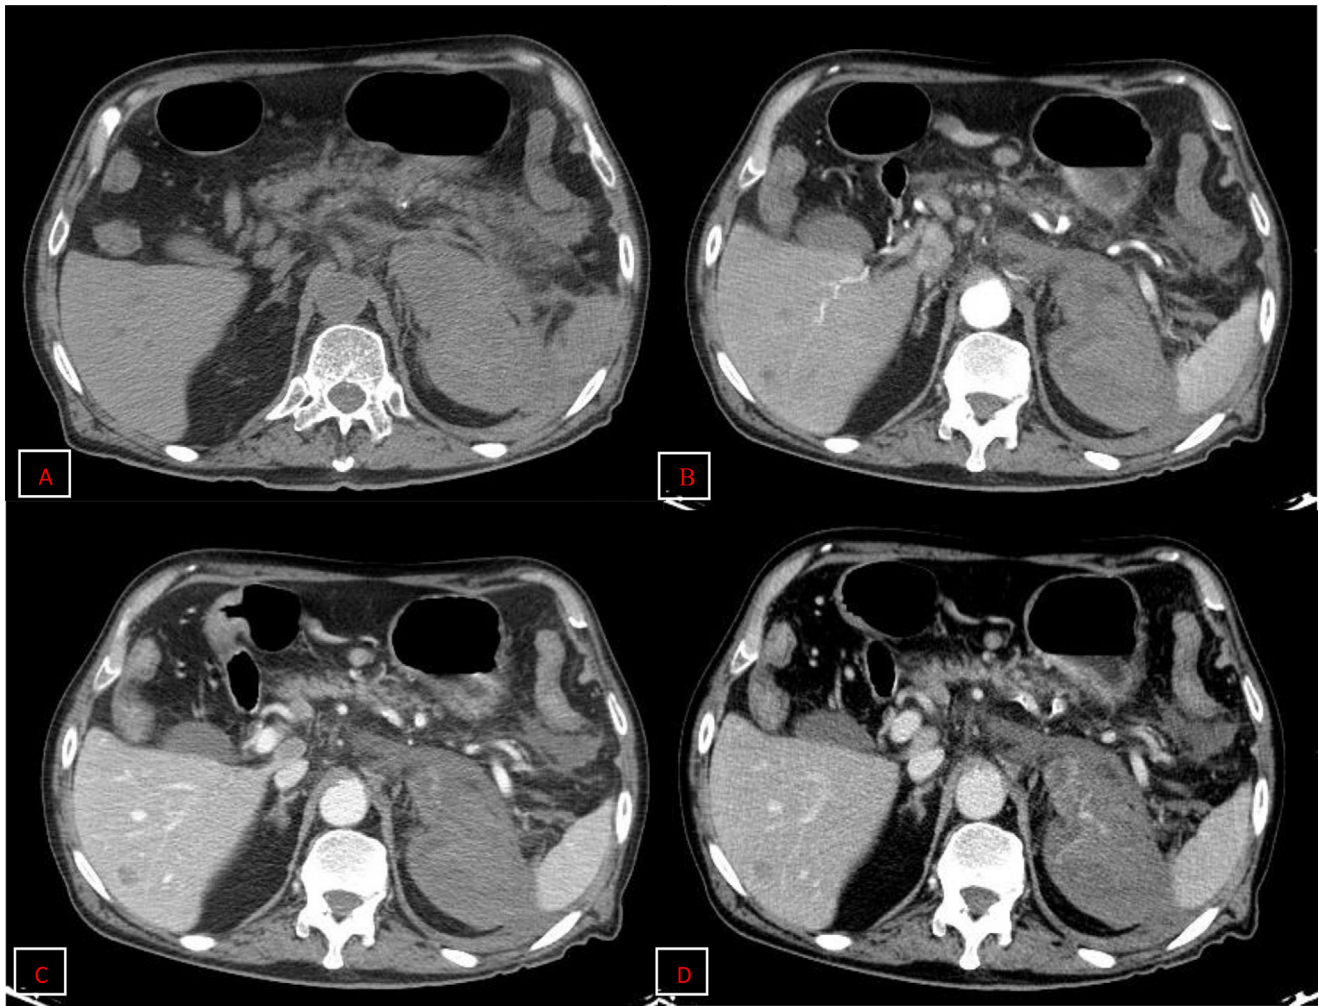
Axial CT documents in the left adrenal loggia collected at partly blood density in the basal phase (A), with signs of active spreading of MdC not clearly recognizable in the arterial phase (B), better evident in the portal phases (C) and above all the late (D) of the contrastographic study, with progressive increase in density and extension.
